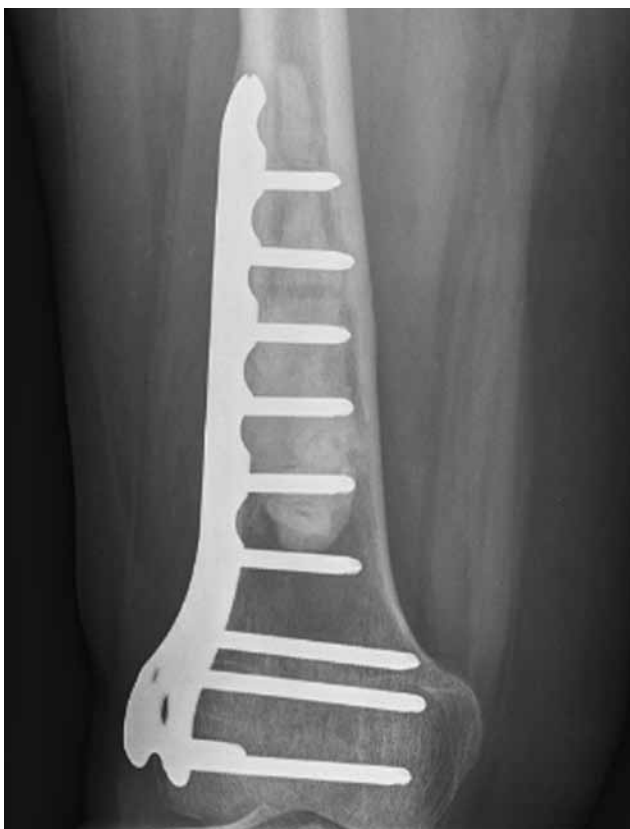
Radiograph after curettage, cryosurgery, cementation, and prophylactic internal fixation.
